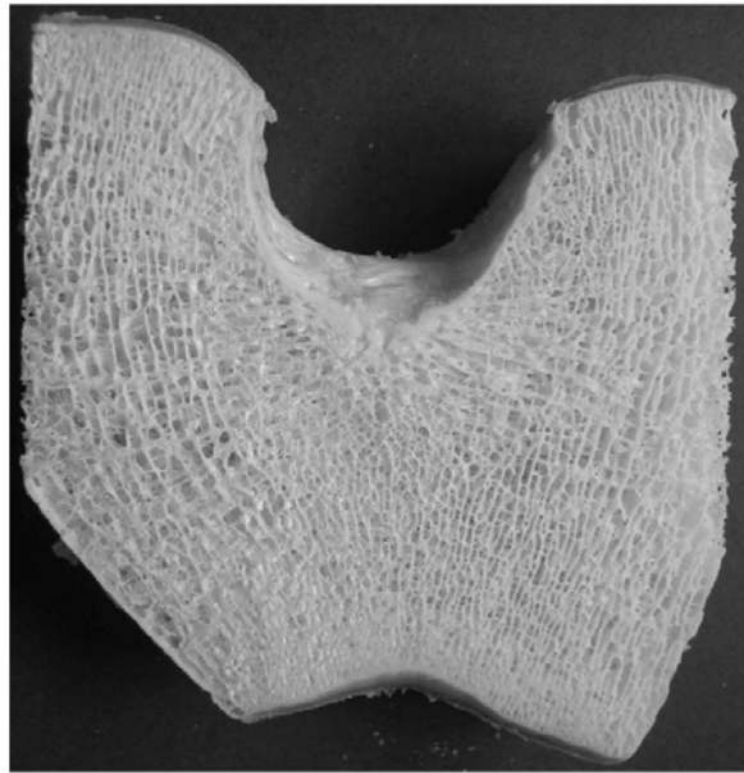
Human calcaneus with lateral cortical endplates removed. Three orientations for ultrasound propagation are shown: superoinferior (SI), anteroposterior (AP), and mediolateral (ML). The most common orientation for ultrasound measurements *in vitro* and *in vivo* is ML.
